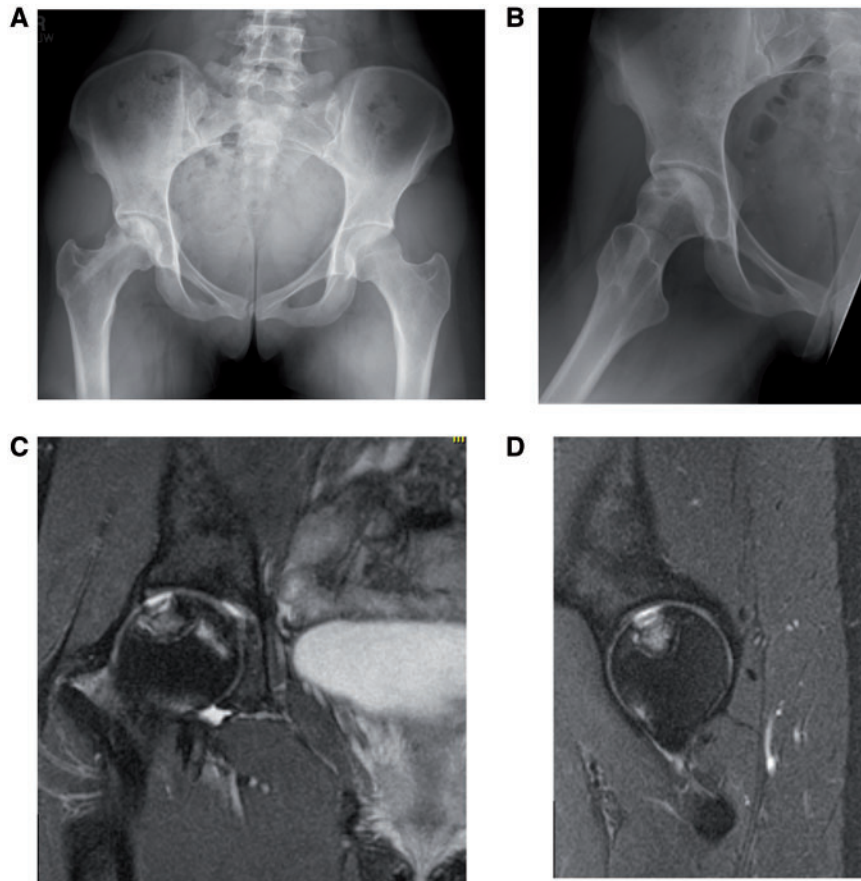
Preoperative imaging. Anteroposterior X-ray view of the pelvis (A) and frog leg lateral view of the right hip (B) of a 25-year-old woman who presented with right hip pain. Her past medical history included nephrotic syndrome which required intermittent treatment with high dose corticosteroids. One year prior to her presentation, she was treated with a core decompression at an outside institution for osteonecrosis of the femoral head which is evident on her X-rays. However, she continued to have pain. Coronal (C) and sagittal (D) magnetic resonance images further characterized the osteochondral lesion with collapse that involved a large area of the weightbearing portion of the femoral head.
